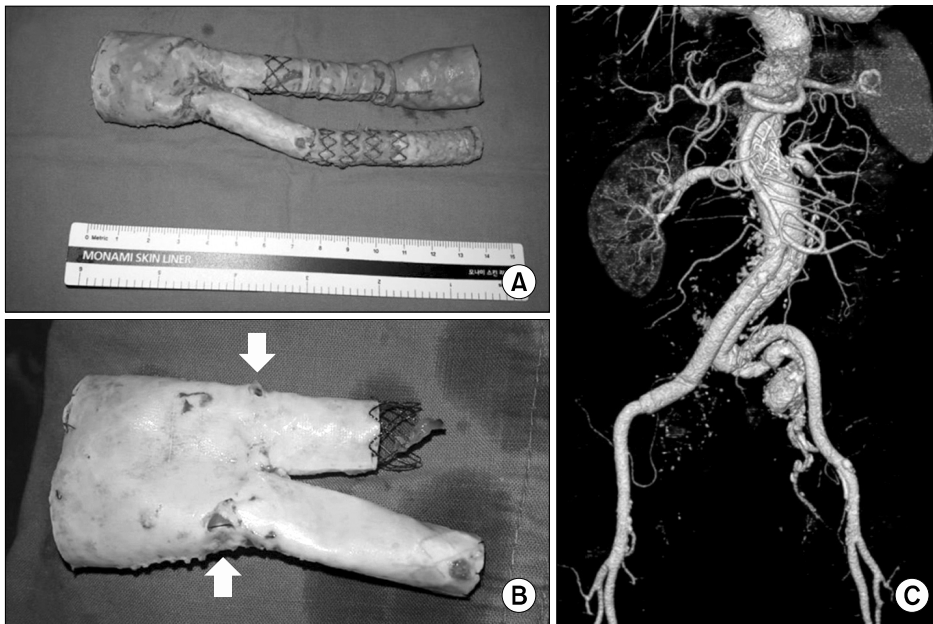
Gross images of the previously inserted SEAL stent graft are shown in A and B. (A, B) The proximal bare-stent portion was left in the patient's aorta. In the main body of the endograft, 2 large holes of over 2 mm in diameter were observed (white arrows). (C) Postoperative computed tomographic angiography after aorto-bi-iliac replacement is shown in a 3-dimensional reconstruction.
